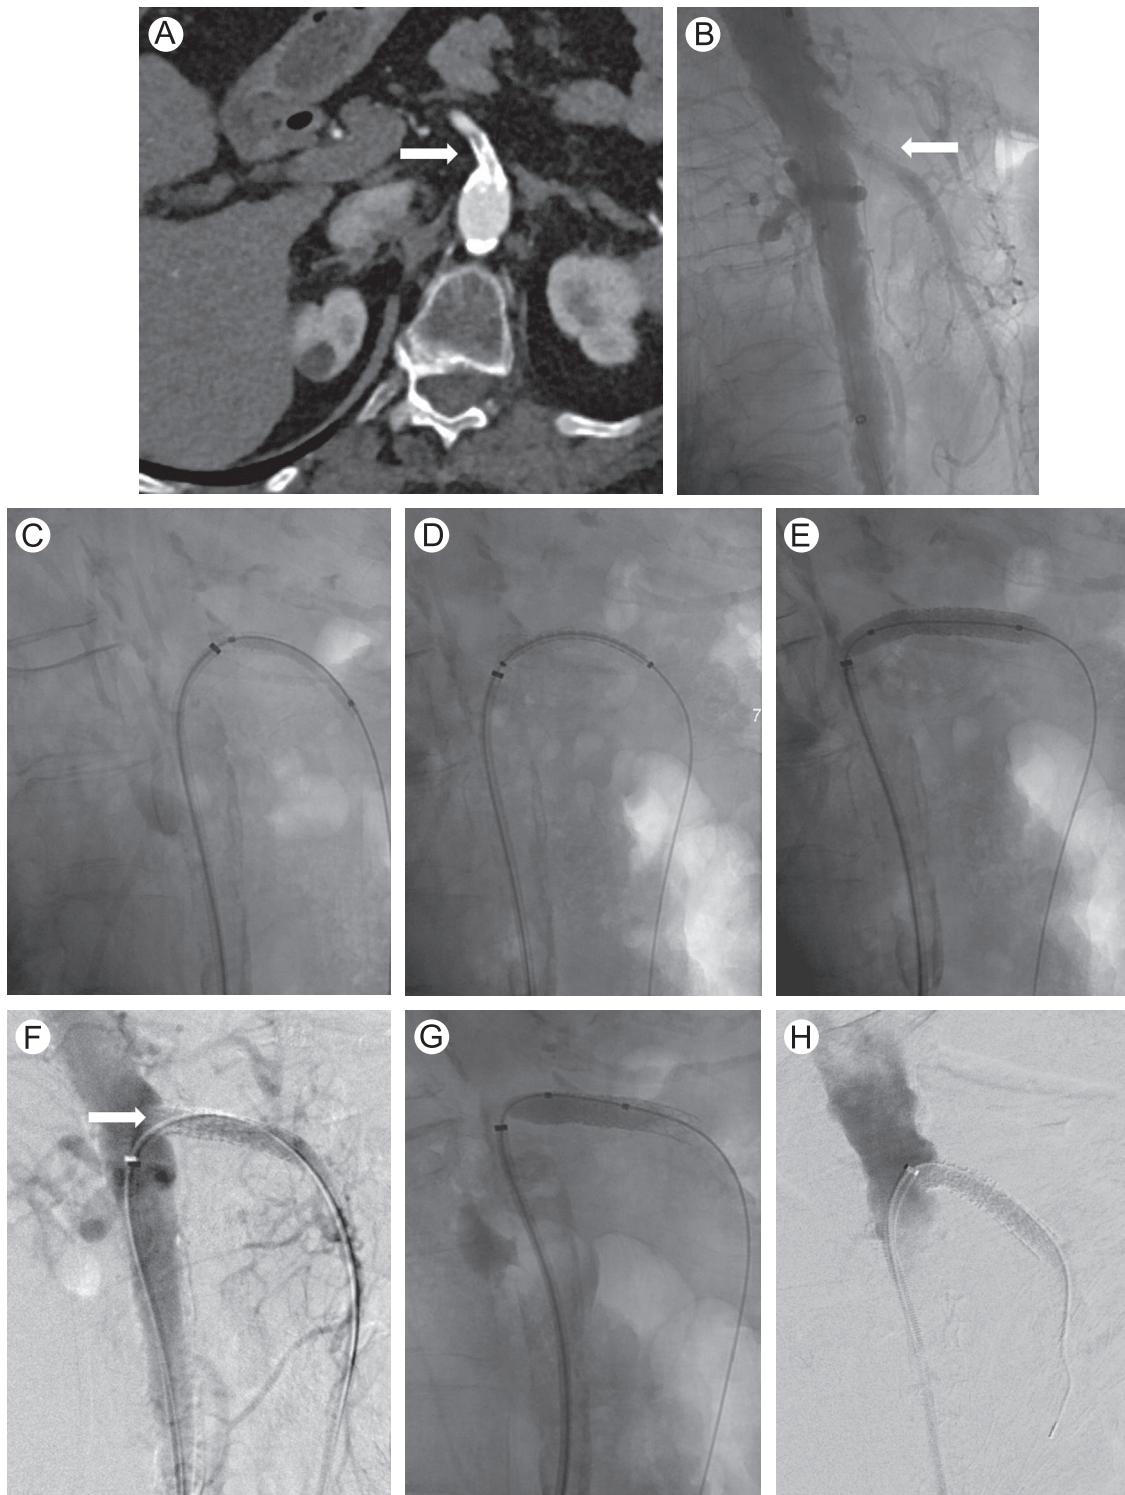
A 63-year-old woman with previously placed balloon expandable stent presented with recent worsening of abdominal pain and food intolerance. (A) Axial image from a CTA shows occlusion of the SMA stent (arrow). (B) Lateral aortogram shows marked narrowing in the previously placed stent, consistent with in-stent restenosis (arrow). (C) Predilation was performed with a 4-mm angioplasty balloon. (D) An iCast of 7 × 38 mm was deployed. (E) Postdilation was performed with a 7-mm balloon. (F) After stent placement, lateral aortogram demonstrates residual narrowing at the proximal margin on the stent. (G) A balloon of 8 × 20 mm was used to flair the proximal edge of the stent. (H) Lateral aortogram shows improved appearance of stent with no significant pressure gradient detected.
